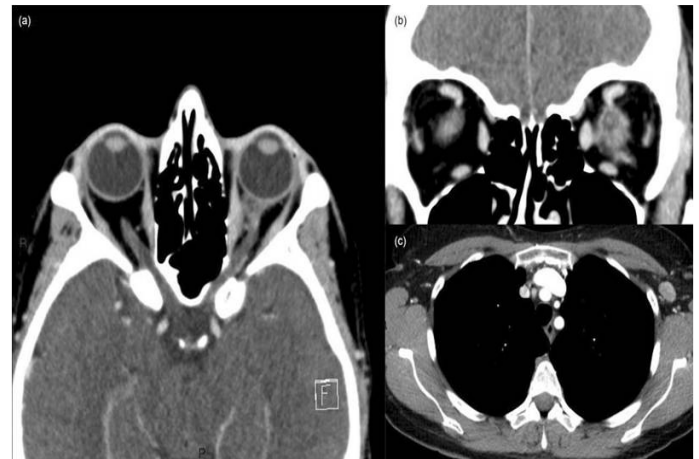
Total body CT with contrast medium
